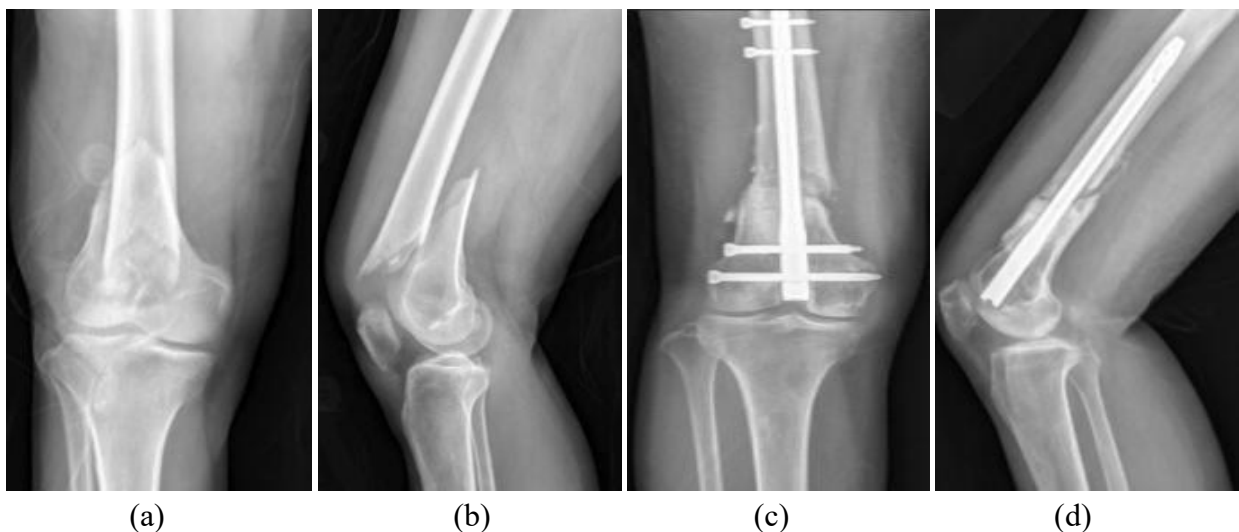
Fig a(a, b): Pre-operative radiographs in AP and lateral views, (c, d): immediate post-operative radiographs.
